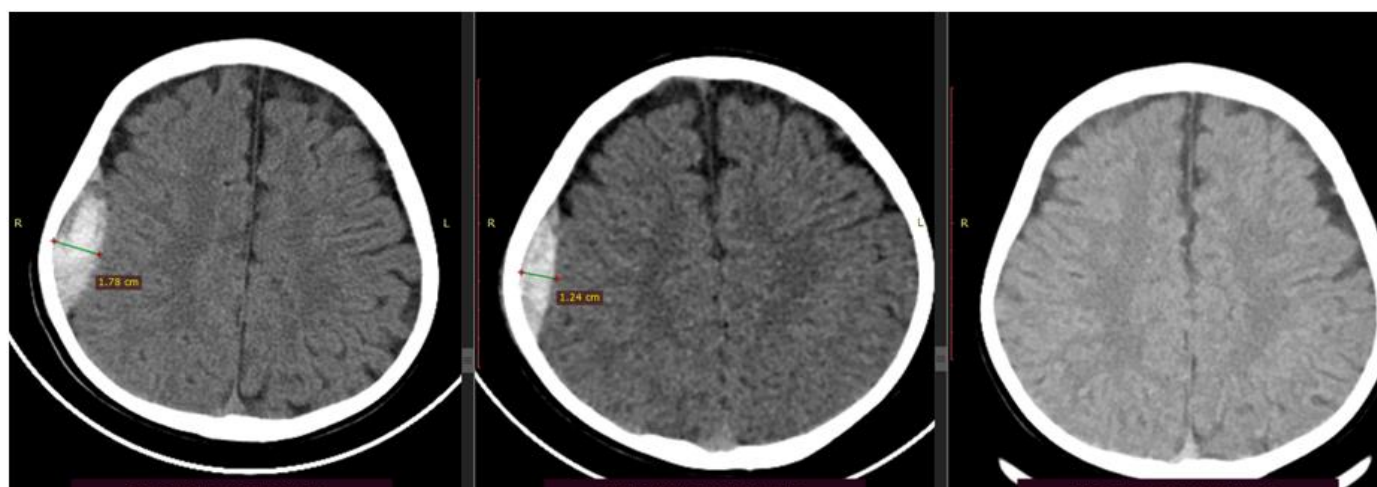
Axial CT scan of a 7-year-old male patient (Patient 14, table 1) shows a right parietal PEDH 18mm in thickness (A). Axial CT scan of the same patient taken 72 hours later shows a little decrease (5 mm) from the earlier scan (B). Axial CT scan of the same patient taken 3 months after discharge demonstrates marked resolution of the EDH (C).
